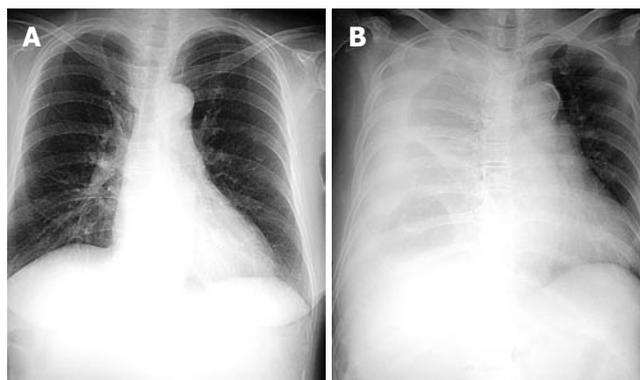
Chest X-ray. A: Before manual compression of the abdomen; B: on the next day, after manual compression of the abdomen.
